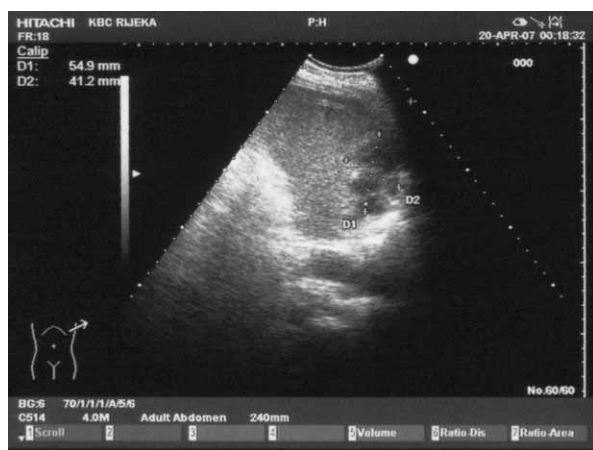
Abdominal ultrasound image showing enlarged spleen (125×45 mm) with hypoechoic area measuring 54×41 mm on convex side of upper pole, and free liquid in left subphrenium.
